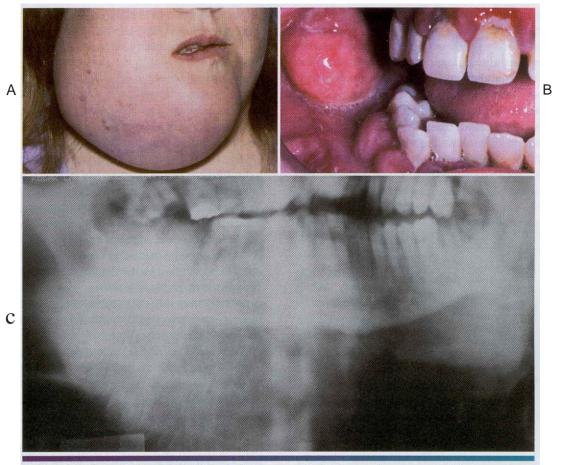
Osteosarcoma. A, This massive tumor had been present for many months before the patient sought treatment. S, Intraoral photograph of the tumor mass. C. The panoramic radiograph shows a "sunburst" pattern of trabeculation within the tumor.
